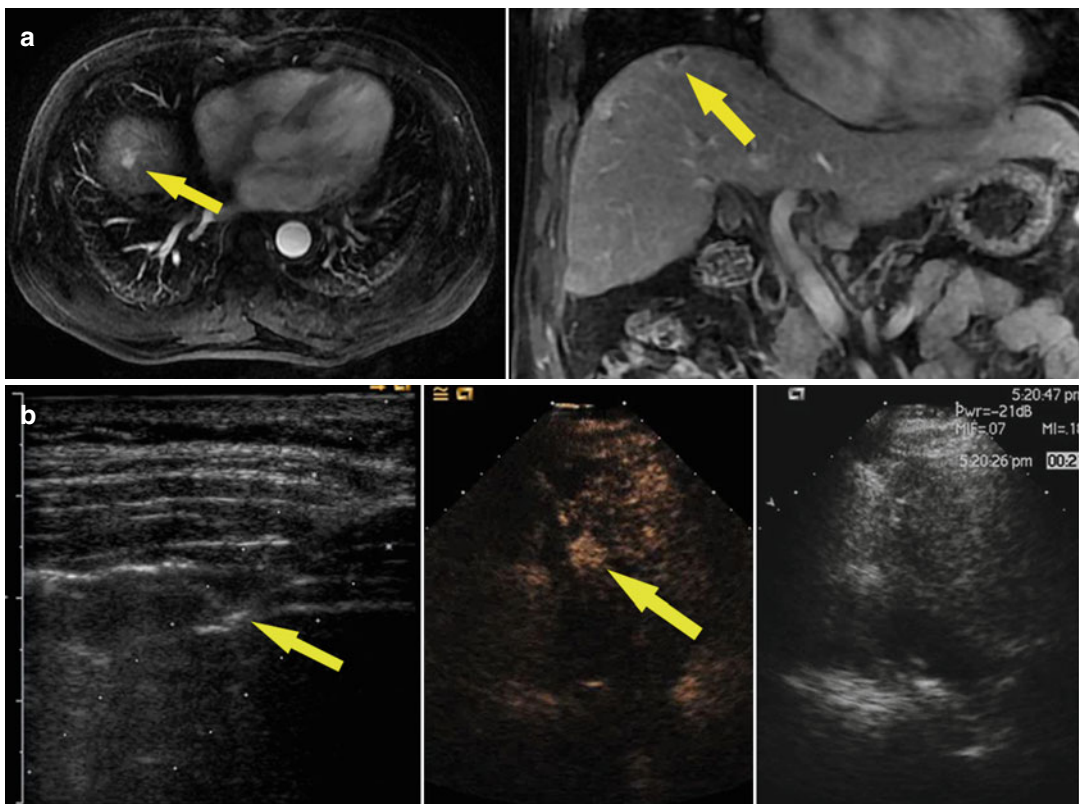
Images in a 58-year-old man with 1.8 cm hepatocellular carcinoma treated by percutaneous microwave ablation (MWA) with artificial pleural effusion. (a) Contrast-enhanced magnetic resonance imaging (MRI) before MWA shows the neoplasm appearing in hyper-enhancement (*small arrow*) on arterial phrase and hypo-enhancement (*large arrow*) on venous phrase. (b) Left sonogram shows the puncture of the pleural cavity with a 16-gauge BD angiocath needle (*small arrow*). The middle
